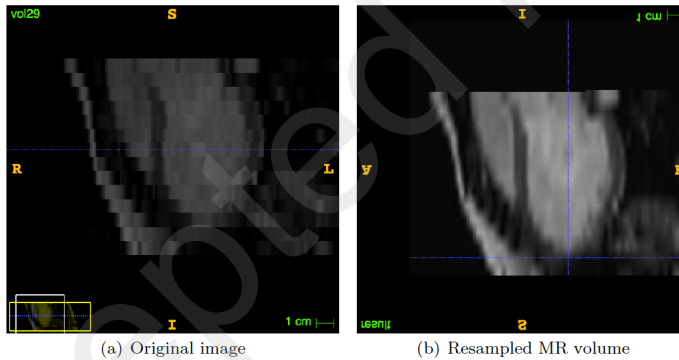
Example of a resampled MRI volume in the longitudinal direction.
